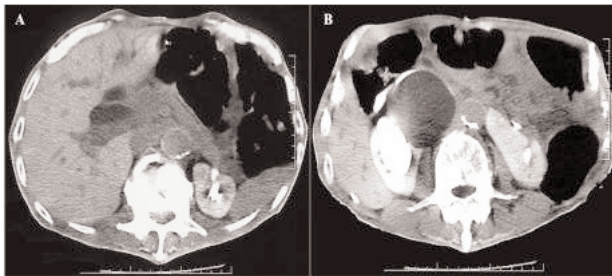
Axial CT scan. Hydronephrosis, dilatation of intra- and extrahepatic biliary tract, and a right renal pseudocyst are confirmed.
